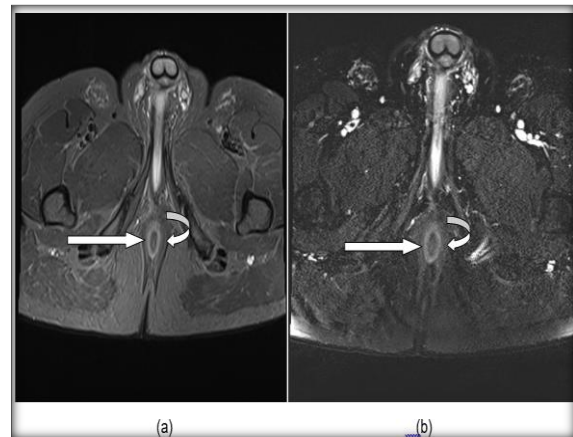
Normal anatomy of Anal Sphincter Complex. (a) Axial STIR and (b) Axial 3D SPACE showing internal anal sphincter (Straight arrow) and external anal sphincter (Curved arrow) which are better delineated in 3D MRI
